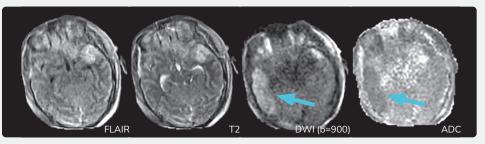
Axial FLAIR, T2, DWI b=900, and ADC images reveal unexpected stroke of the right temporal lobe with DWI-FLAIR mismatch (arrows).
